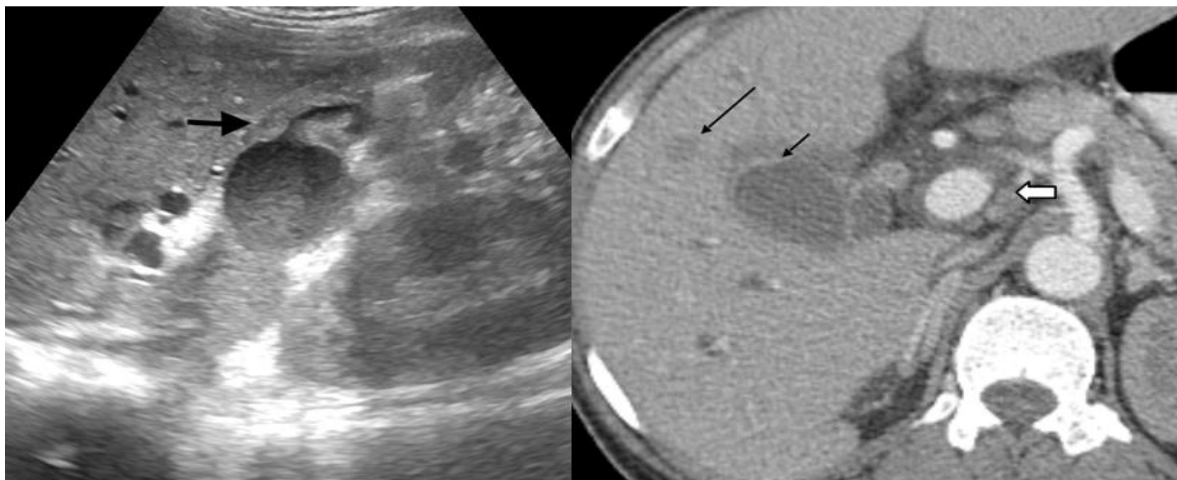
55 years old, male: Trans abdominal USG shows focal eccentric irregular hypoechoic wall thickening (black arrow) in fundus and body of gall bladder. No calculus is seen. Figure 3b: Contrast enhanced CT Scan of abdomen reveals focal eccentric irregular thickened enhancing wall in fundus and body of gall bladder (small black arrow), small mildly enhancing metastatic hepatic nodule (long black arrow) and enlarged periportal lymph nodes (small white arrow).
